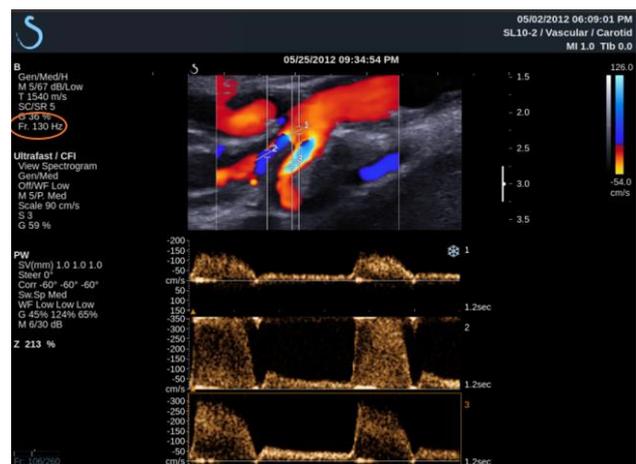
Ultrafast Doppler of a carotid stenosis (from ref [27])
